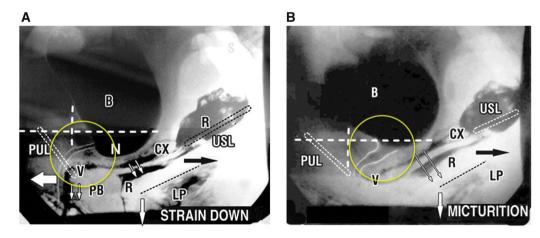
Sitting sagittal X-ray view with radiopaque dye in the bladder(B), vagina (V), rectum (R), and levator plate (LP). (A) Urethral closure. Three opposing directional forces (arrows) stretch the vagina in opposite directions around competent pubourethral ligament (PUL) to close the distal and proximal urethra and to support bladder base stretch receptors (N). Note the action of the backward/downward vector forces (arrows) against the uterosacral ligament (USL). The yellow circle represents the zone of critical elasticity (ZCE) in the bladder neck area of the vagina. This allows the separate action of the opposite muscle vectors (arrows). If ZCE (yellow circle) is scarred or extended by previous Burch surgery, the posterior vectors overcome the forward vector, so the bladder opens exactly as occurs during micturition. (B) Micturition. The forward vector relaxes. This allows the backward/downward vector forces (arrows) to contract against a competent USL to open out the posterior urethral wall, expanding the outlet tube, exponentially decreasing the resistance to emptying of the bladder.
